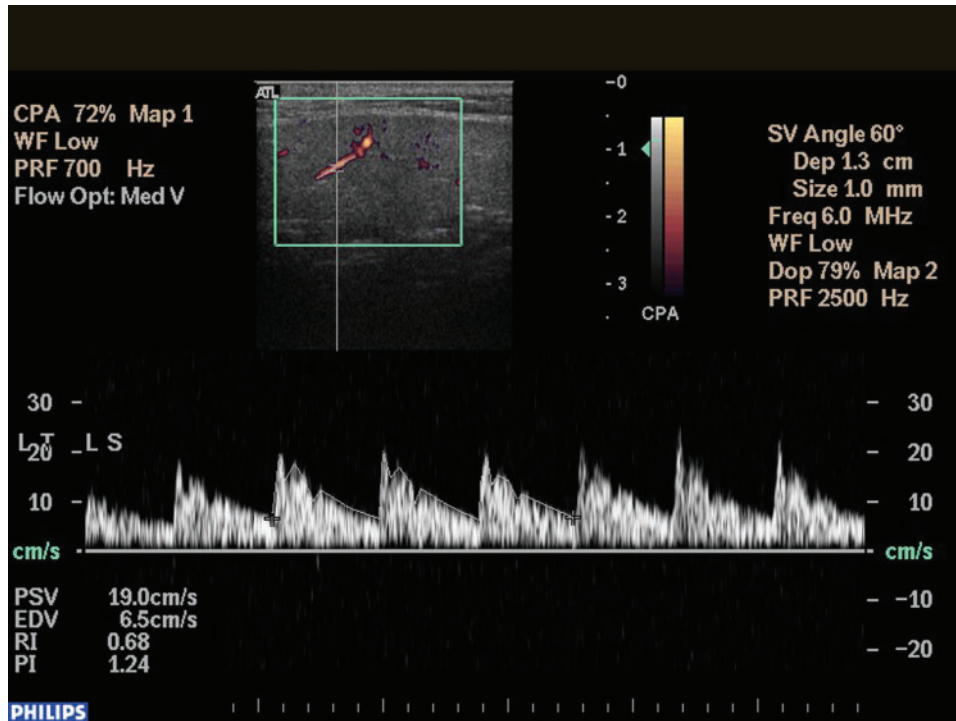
Spectral Doppler sonogram showing the measurement of blood flow velocity (peak systolic velocity (PSV) and end diastolic velocity (EDV)) and vascular resistance (resistive index (RI)) of a normal parotid gland. Note the average of the measurements is obtained from three consecutive waveforms.
